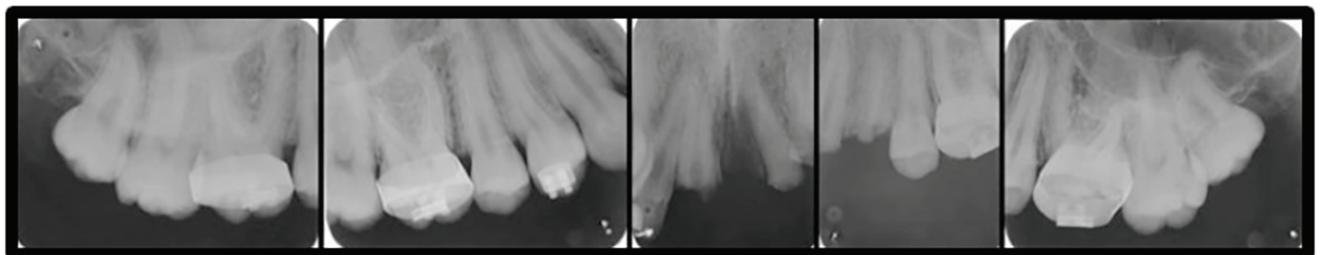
Postmortem periapical radiographs of the maxilla.
